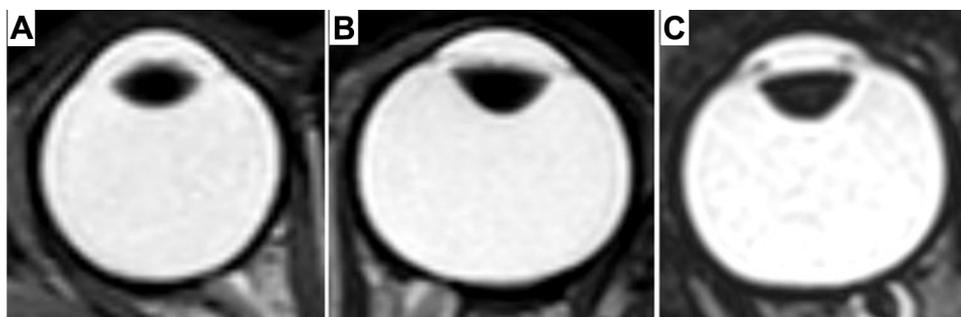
Axial T2-weighted magnetic resonance imaging (MRI) of control and case lenses showing a normal lens (A), a lens with posterior lenticonus in patient 1 (B), and a lens with posterior lenticonus in patient 2 (C).
